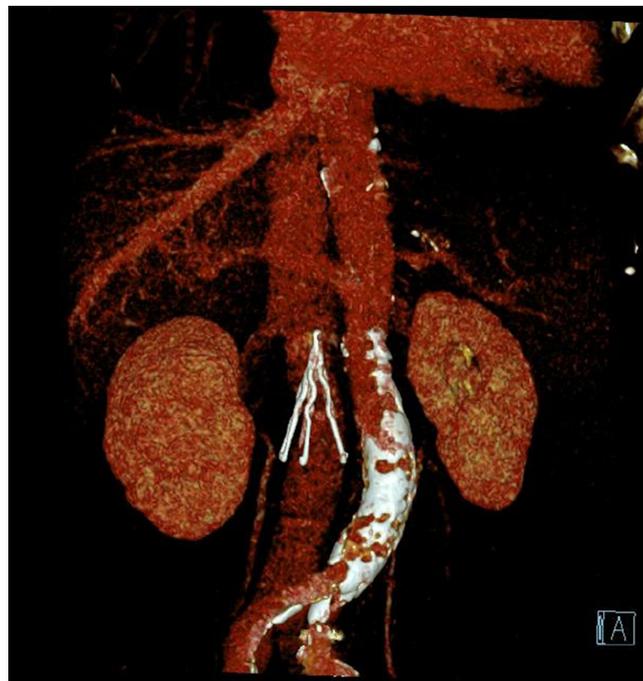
CT shows inferior vena cava filter.
